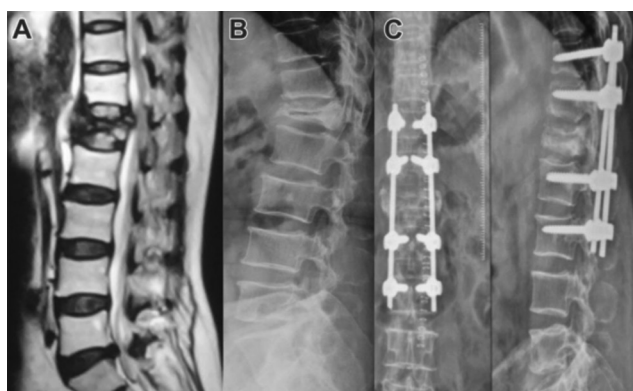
Posterior approach long-segment fixation (LSF): (A) Preoperative magnetic resonance imaging, (B) preoperative X-ray, and (C) postoperative LSF.
